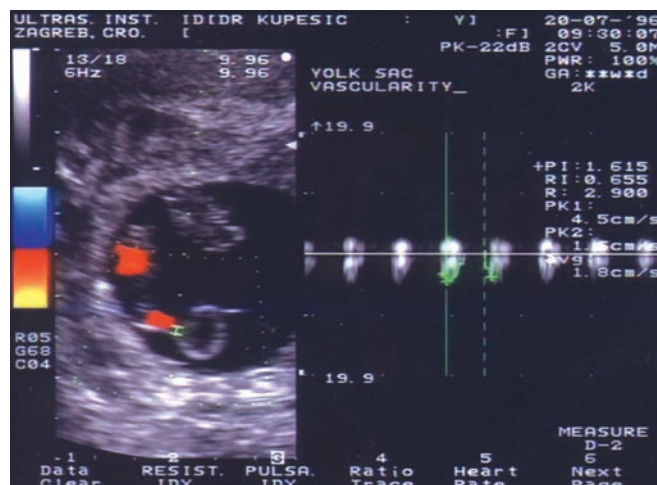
A color image of the yolk sac at 7 weeks' gestation. Pulsed Doppler signals isolated from the connection of the yolk sac and vitelline duct show absence of diastolic flow.
